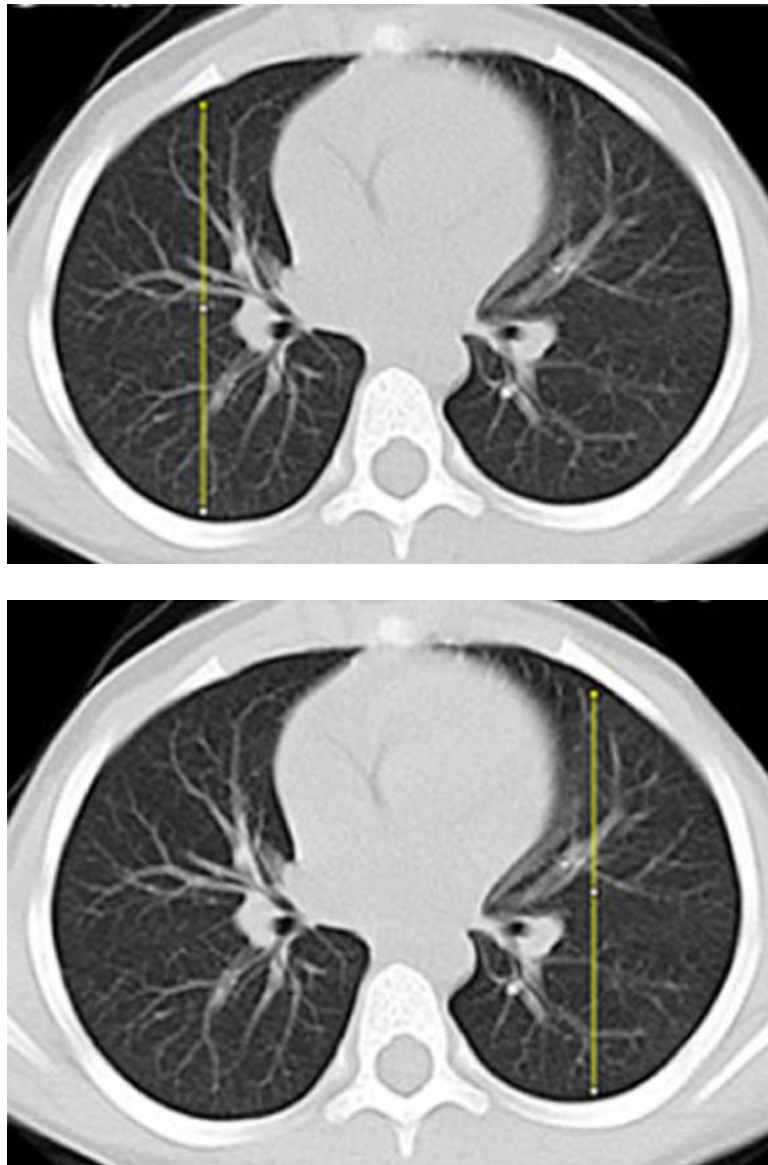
Image analysis of lung attenuation. Non-contrast axial CT images through the thorax in a 46-month-old boy demonstrate the method used to measure gravitational dependence of lung attenuation with ImageJ. Four linear plot profiles were obtained in each child, located in each upper lung at the level of the carina (a, b), and in each lower lung at the approximate level of the basilar segmental bronchi origins (c, d)
